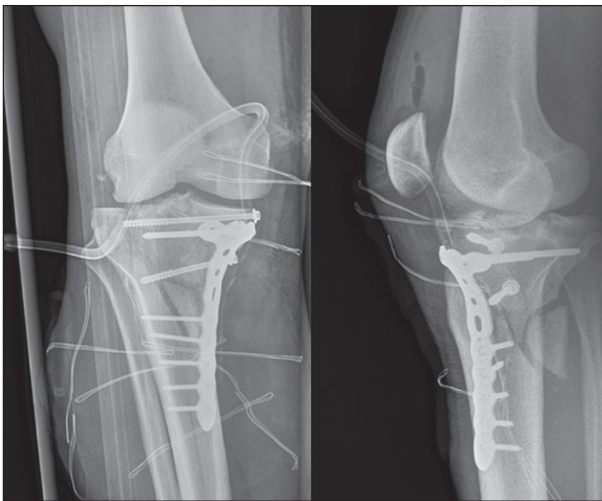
Post-operative X-rays following ORIF with plate and screws and bone graft.
